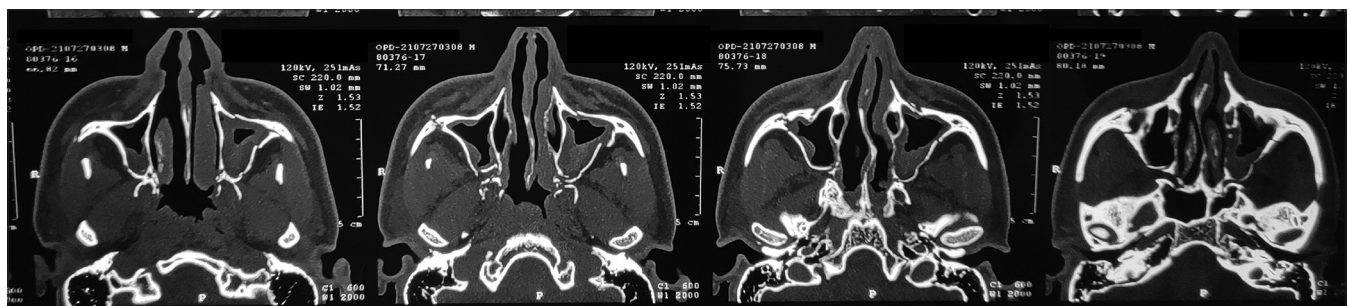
Computed tomography (axial section). Fractures are noted involving bilateral nasal bone, ethmoidal septae, bilateral medial, and lateral walls of pterygoid, bilateral greater wing of sphenoid and bilateral maxillary sinuses associated with hem sinus
